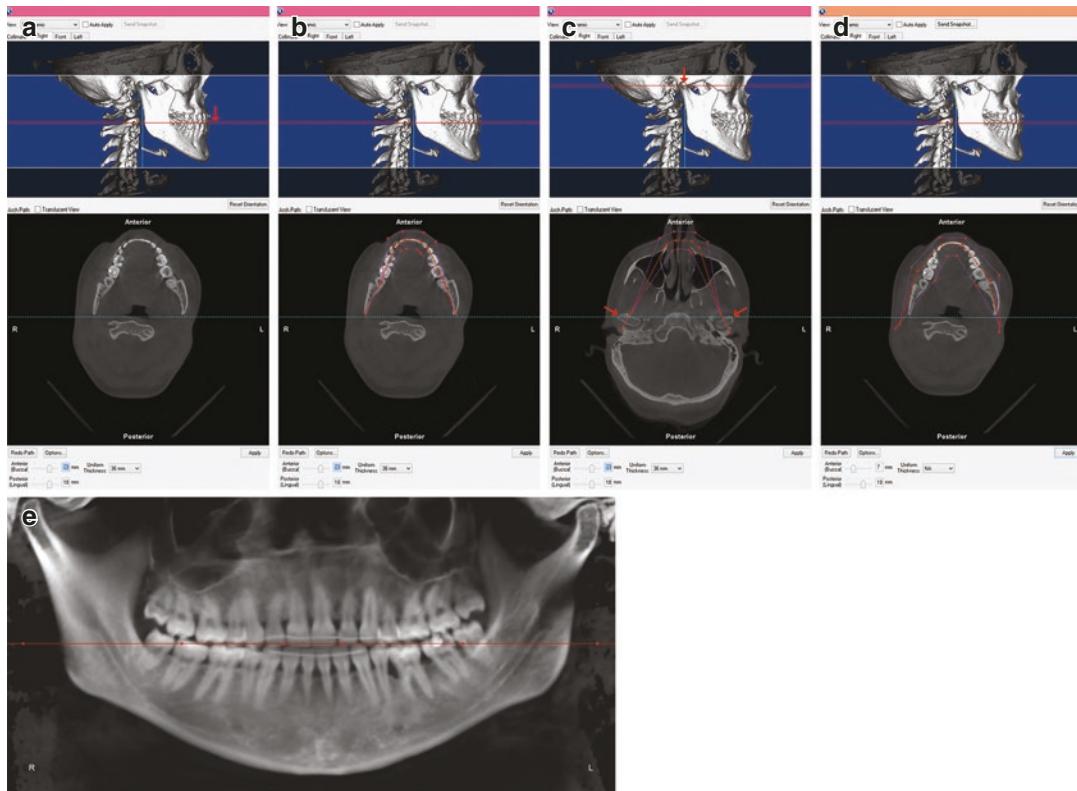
Showing the necessary steps to acquire a CBCT-generated panoramic radiograph. (a) The highlighted region on top image represents the superior and inferior borders of the panoramic film. The head is oriented to coincide the axial slice (red line marked with arrow) with the occlusal plane so that all the teeth on dental arch is visible. (b) Defining path using the dental arch as a reference (bottom image). Note that the condyles are
